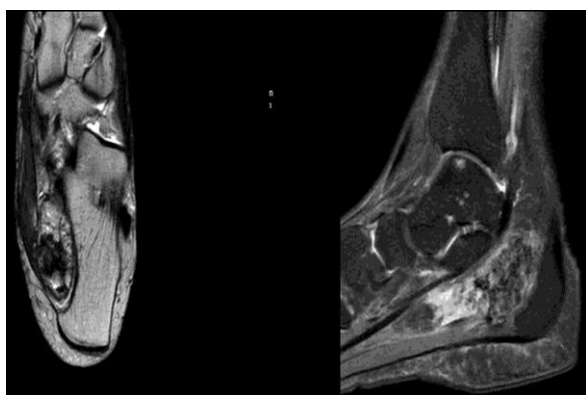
Magnetic resonance images showing calcified mass noted in the Quadratus plantae muscle. No focal lesions or joint effusion noted
